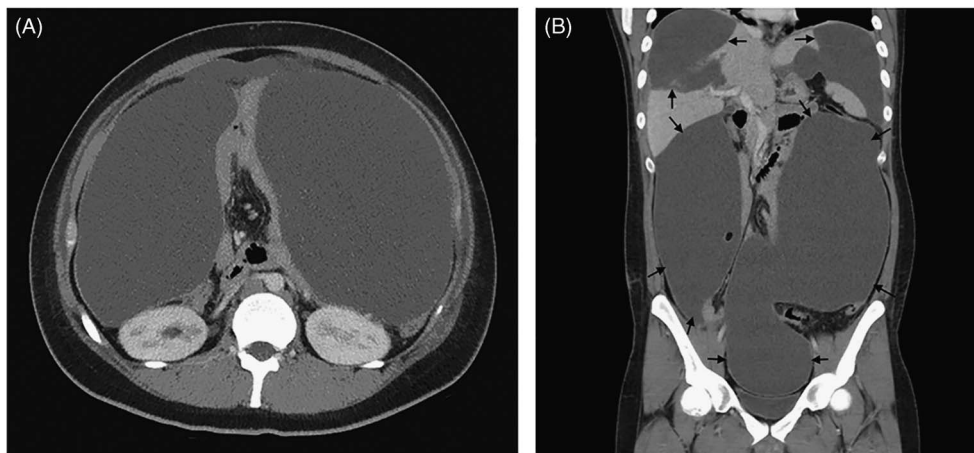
and 2B. Follow-up contrast-enhanced CT scan obtained three weeks later demonstrated an extensively large amount of intrahepatic low attenuation fluid collection with slightly thickening peritoneum causing mass effects to bowel loops.
